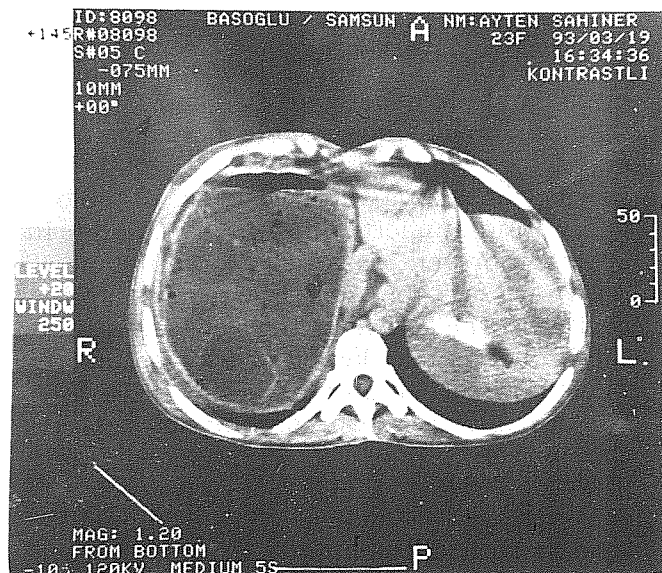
Hepatopleural fistula by causing multiple liver echinococcosis cysts seen by means of thoracoabdominal computed tomography.
